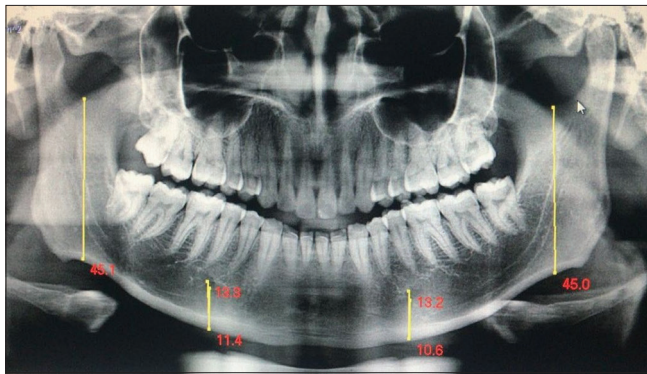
Panoramic radiograph showing measurements of ramus height and dimensions of superior and inferior aspects of mental foramen on both right and left side
